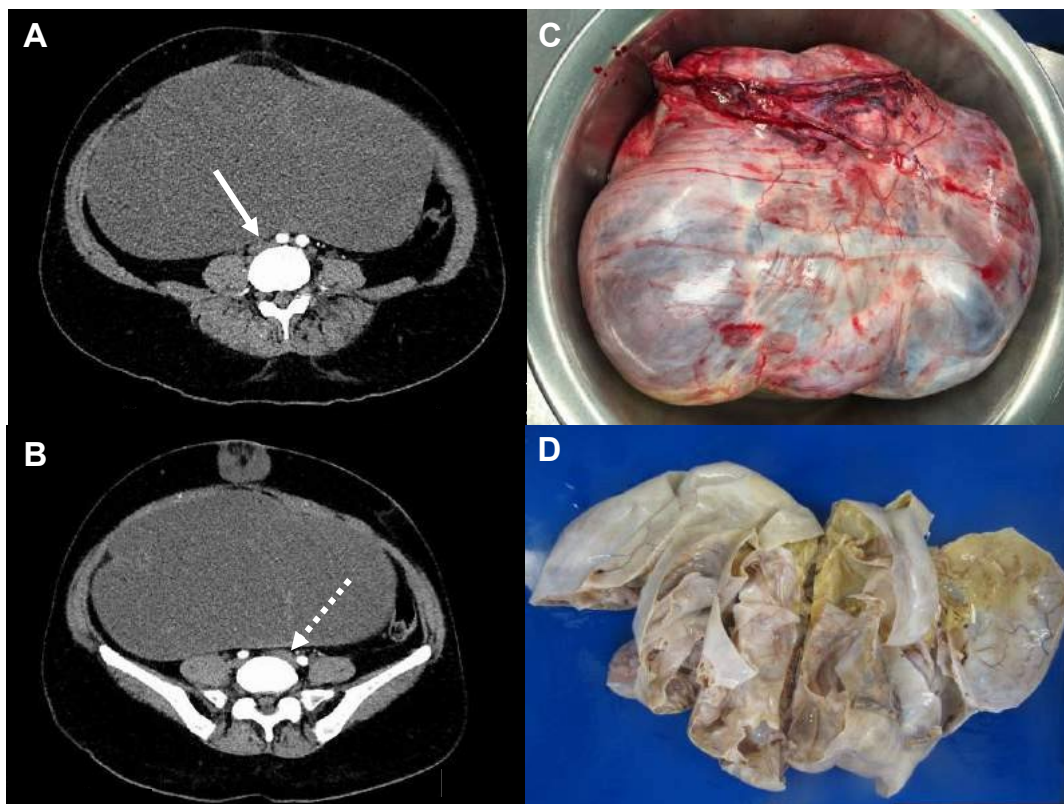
A) Axial CT showing large septated likely ovarian mass compressing the inferior vena
